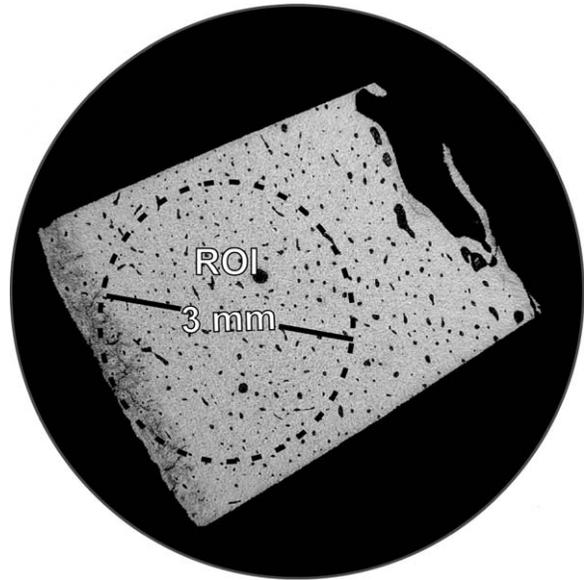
An example of a region of interest (ROI) on one transverse X-ray of bone. Low BMD along the periosteal surface may complicate analyses and, if so, is removed if the region is not too large.
